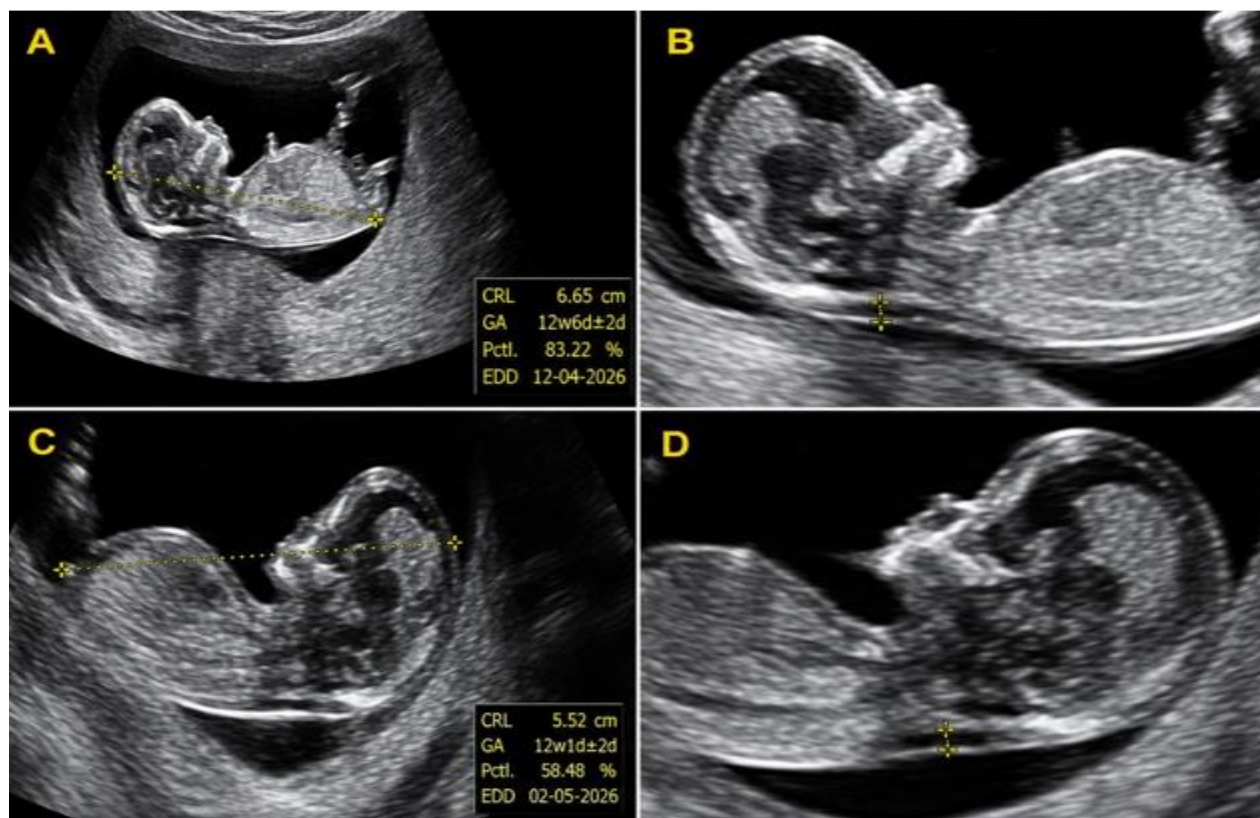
Representative first-trimester ultrasonographic images demonstrating crown–rump length (CRL) and nuchal translucency (NT) measurements. (A) Mid-sagittal fetal image showing CRL measurement of approximately 66 mm, corresponding to a gestational age of 12 weeks 6 days. (B) Mid-sagittal fetal image demonstrating NT measurement of approximately 1.51 mm. (C) Mid-sagittal fetal image showing CRL measurement of approximately 55 mm, corresponding to a gestational age of 12 weeks 1 day. (D) Mid-sagittal fetal image demonstrating NT measurement of approximately 1.69 mm.
